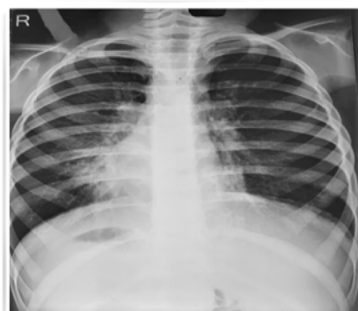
X-Ray suggestive of dextrocardia
